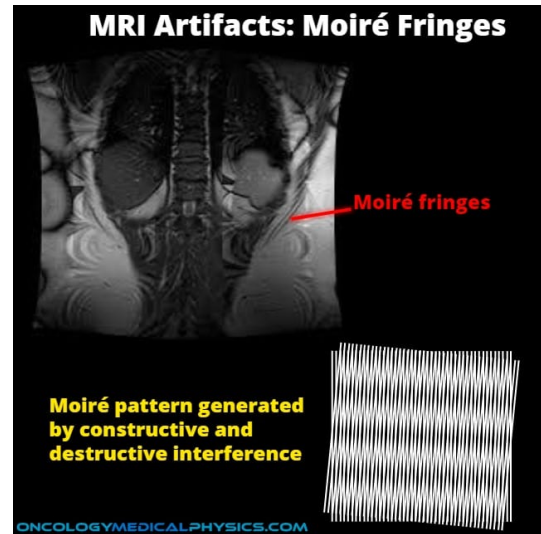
Example of Moiré fringes as an MRI artifact. [28]
